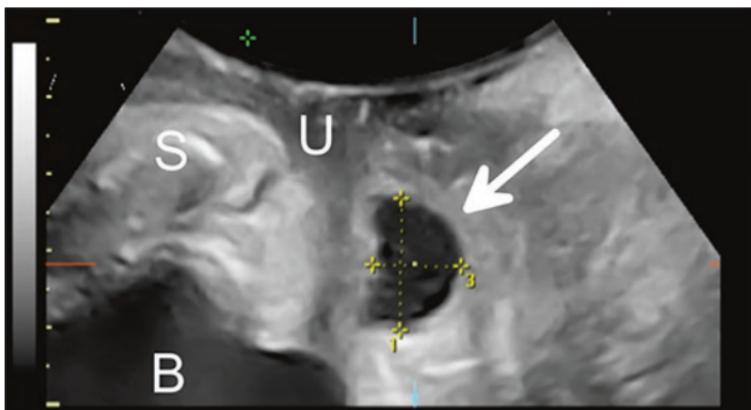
Urethral diverticulum imaged by 3D translabial ultrasound in the midsagittal plane (arrow). S, symphysis pubis; B, bladder; U, urethra. Courtesy of Professor Hans Peter Dietz, University of Sydney
